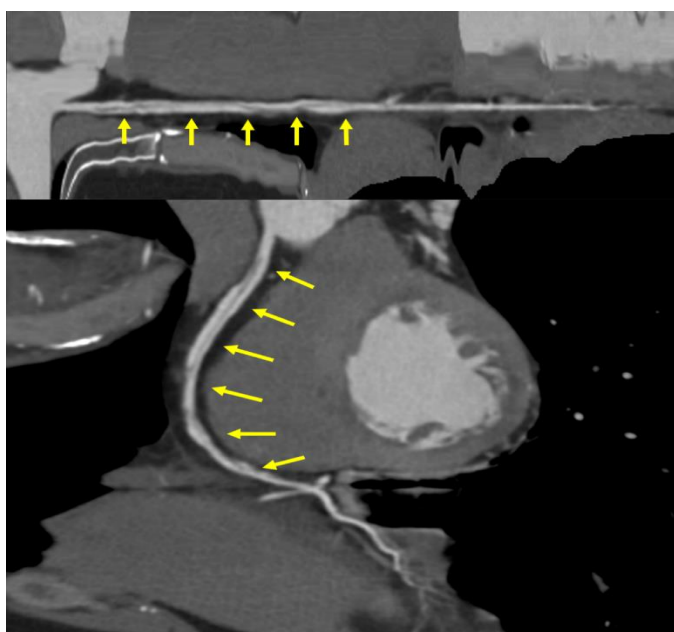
Coronary computed tomography.
